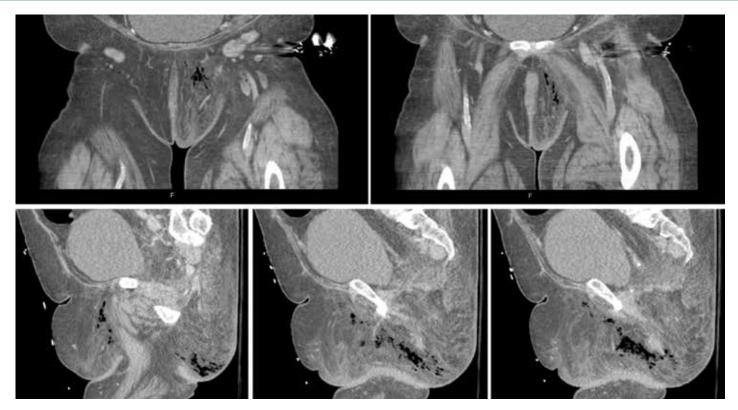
CT scan of our patient on presentation. A. & B. Frontal slices demonstrating pneumolabium. C., B., & E. Axial slices demonstrating subcutaneous emphysema tracking through the perineum.
